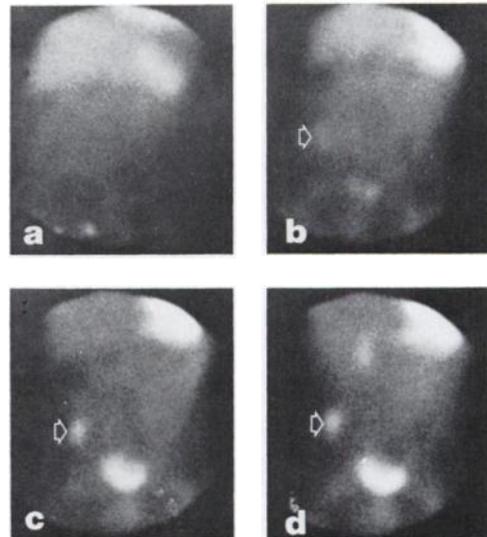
Typical positive scintigrams in a child with a bleeding Meckel's diverticulum that contained ectopic gastric mucosa; 10 min (a), 20 min (b), 30 min (c), and 50 min (d) after pertechnetate injection. Arrows indicate lesion.
